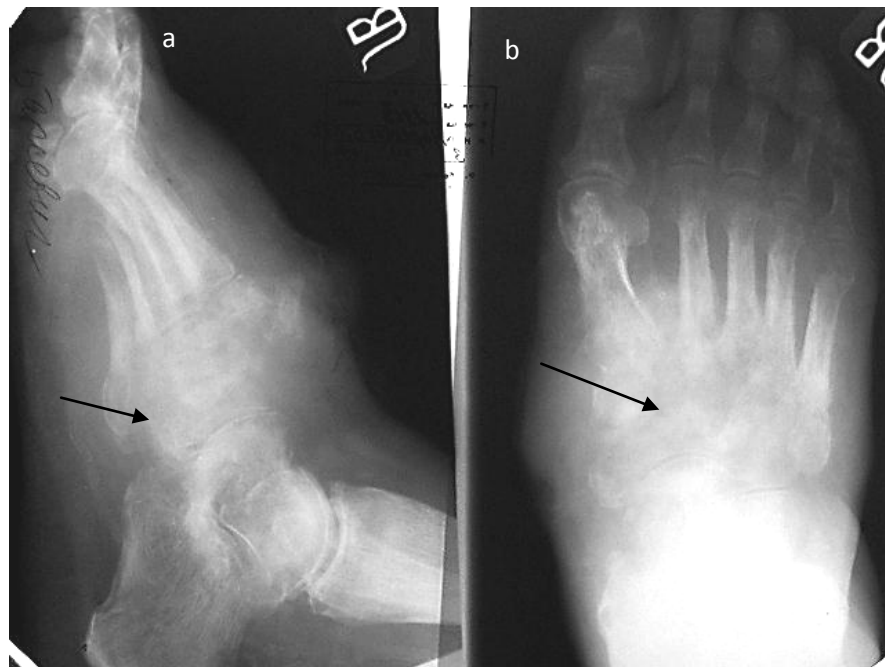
The radiographs of the foot in lateral (a) and direct (b) projections. Destruction of naviculare, cuboideum, cunifome bones and proximal epiphyses metatarsi bones (arrow), indistinct contours of joint surfaces of these bones. Osteoporosis of calcaneal and ankle bones. Tubercular ostitis of the foot
